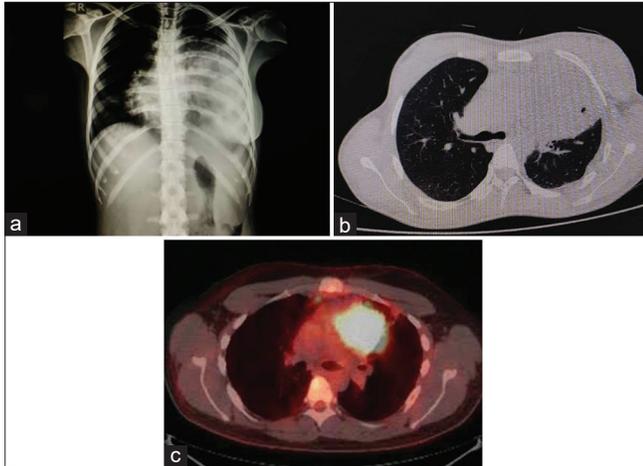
(a) Chest X-ray, (b) contrast-enhanced computed tomography chest, (c) positron emission tomography scan.
